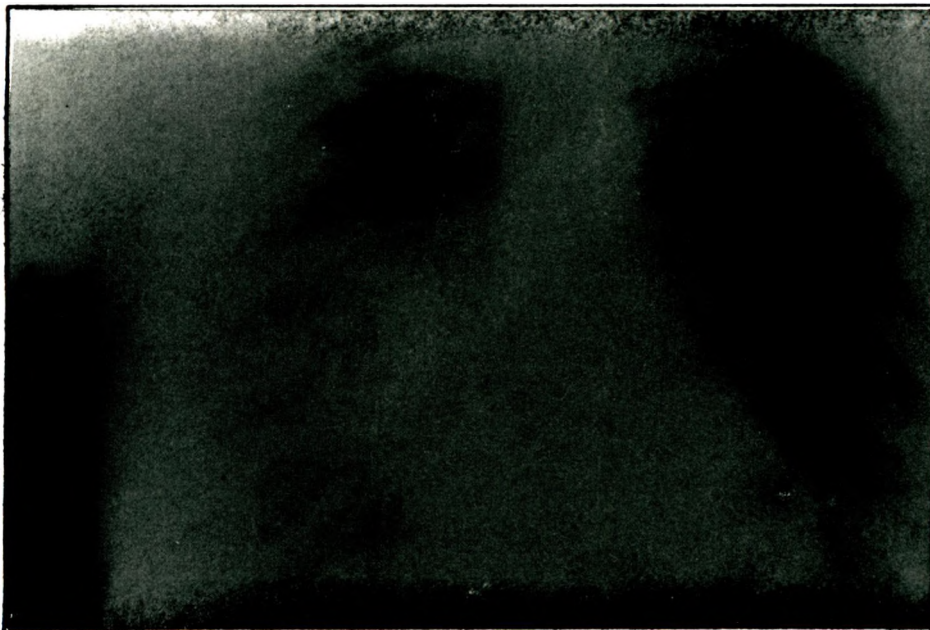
P-A chest x-ray showing diffuse infiltration.
